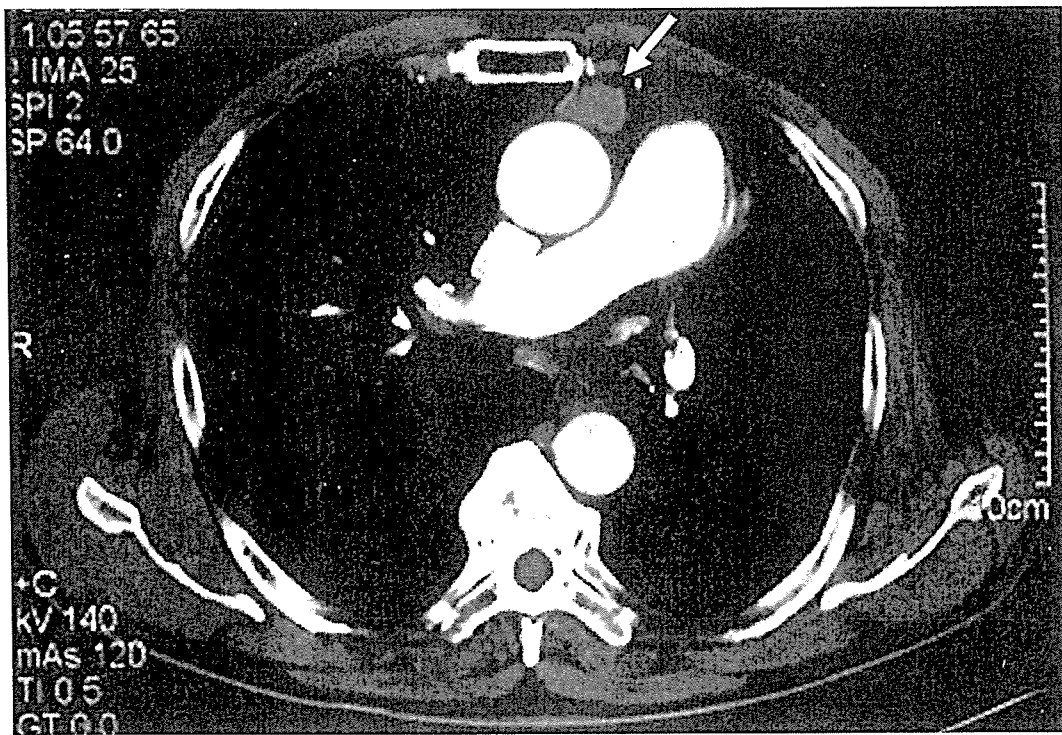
Case 1. Computed tomogram (CT) showing well-defined mass (arrow) bound on the ascending aorta.
